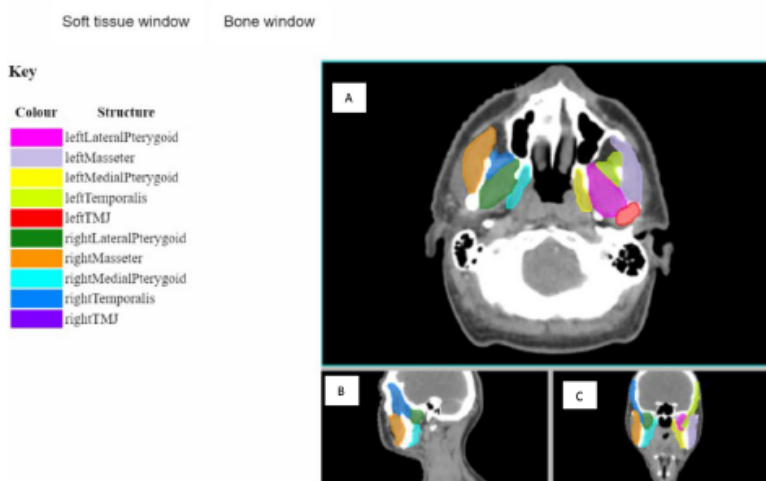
Overview of the masticatory muscles atlas showing axial (A), sagittal (B) and coronal (C) slices. The right TMJ is not visible on the CT slice shown in Figure. www.bit.ly/trismusatlas (to access the webpage please open with google chrome version 56 or opera version 43).
